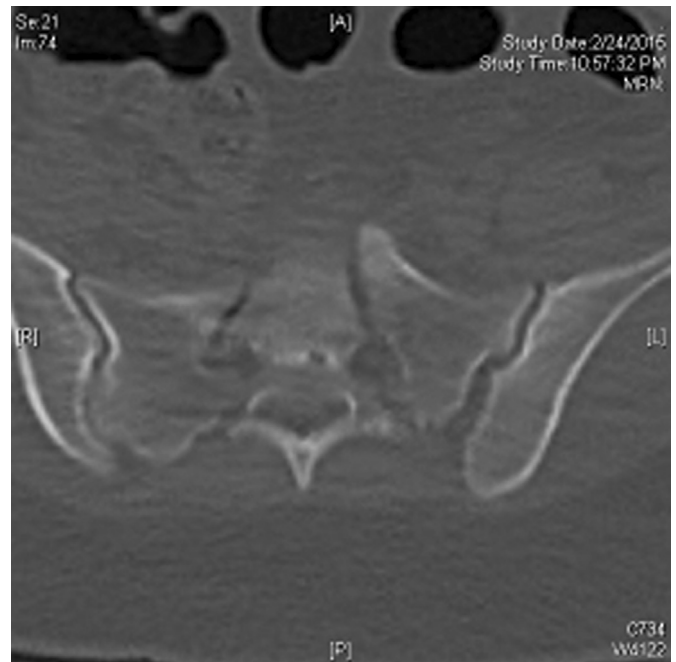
Plain CT-scan of pelvis showing bilateral sacral fractures.
